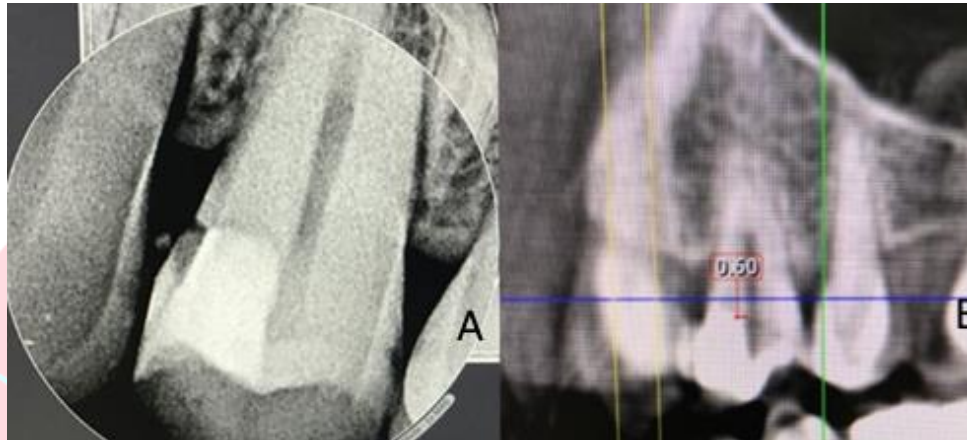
X-ray image of tooth 24 after placement of BIODENTIN; B. CBCT of tooth 24. The location of the dental pulp at 0.6 mm from the restoration is visible.
